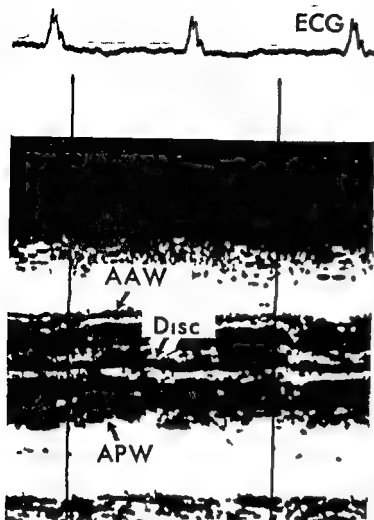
Echocardiogram of the aortic root in a patient with extensive clot formation in and around the valve. Dense echoes fill the lumen of the aortic root and the posterior wall of the aortic root (APW) cannot be clearly identified. The linear echo in the center of the lumen may represent the disc of the Björk valve. (From Ben Zvi et al. *Am J Cardiol* 34:538, 1974.)
